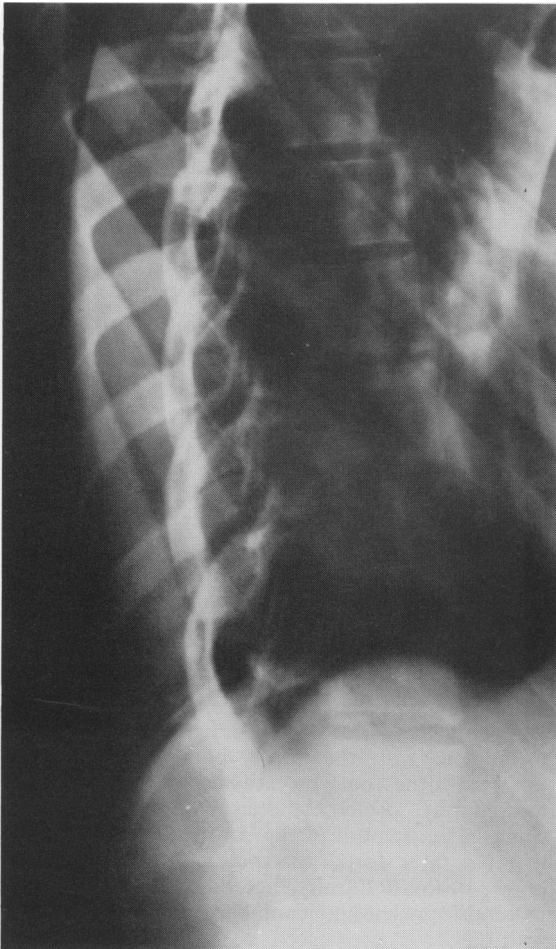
Postero-anterior radiograph of a patient with idiopathic thoracic scoliosis. There is a lateral curvature of the spine with rotation such that the spinous processes are directed towards the curve concavity.*
